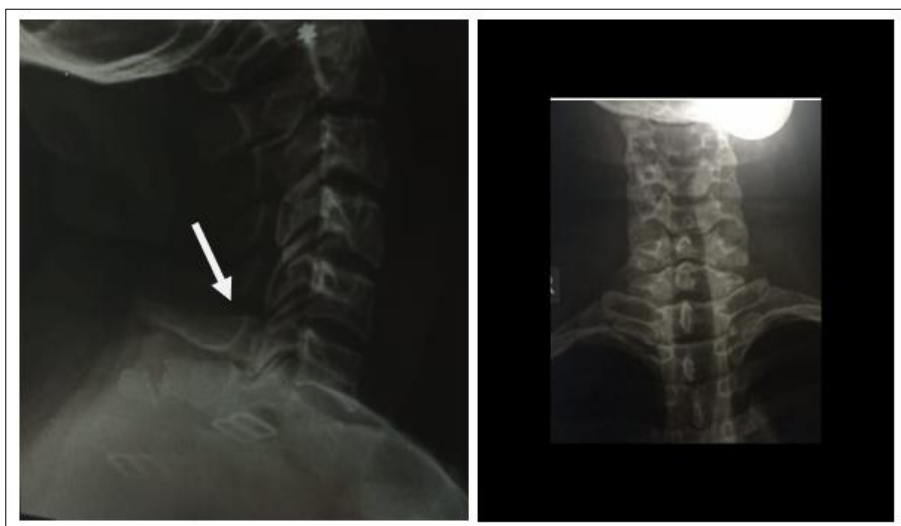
Cervical X-ray lateral view showing Fracture of C7 Spinous process (arrow)
